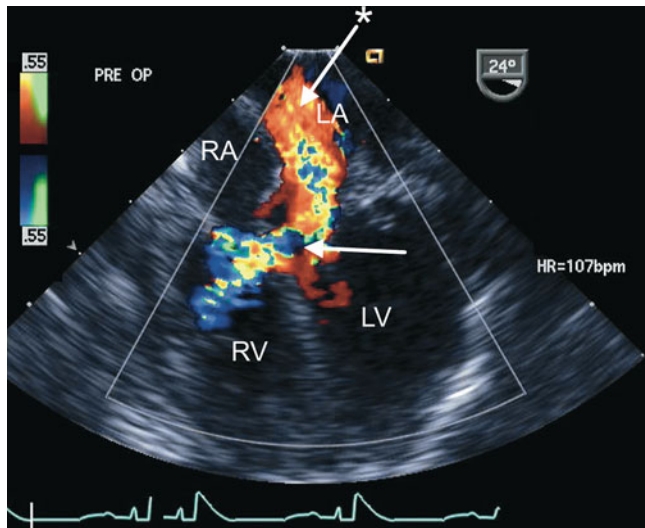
Preoperative transesophageal echocardiogram in an infant requiring reoperation to address a residual inlet ventricular septal defect (*arrow*) as well as significant regurgitation across a large left atrioventricular valve cleft related to suture dehiscence (*arrow with asterisk*). Both lesions are well characterized by color flow imaging in the mid esophageal four chamber view. *LA* left atrium, *LV* left ventricle, *RA* right atrium, *RV* right ventricle
